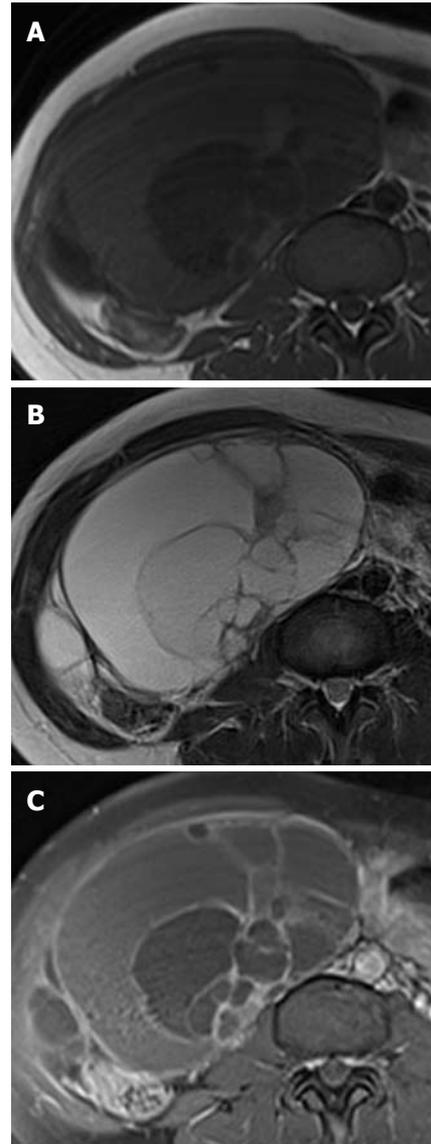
Mucinous borderline tumor of the right ovary in a 41-year-old woman. A, B: T1- (A) and T2-weighted (B) MR images show a cystic mass with large numbers of loculi with varying signal intensity in the right ovary; C: Contrast-enhanced fat-saturated T1-weighted MR image shows the enhancement of multiple internal septa and wall in the cystic mass. MR: Magnetic resonance.
